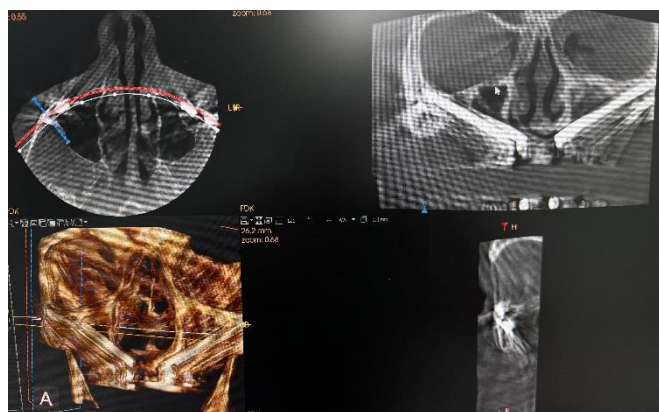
CBCT at 12-month follow-up.*
